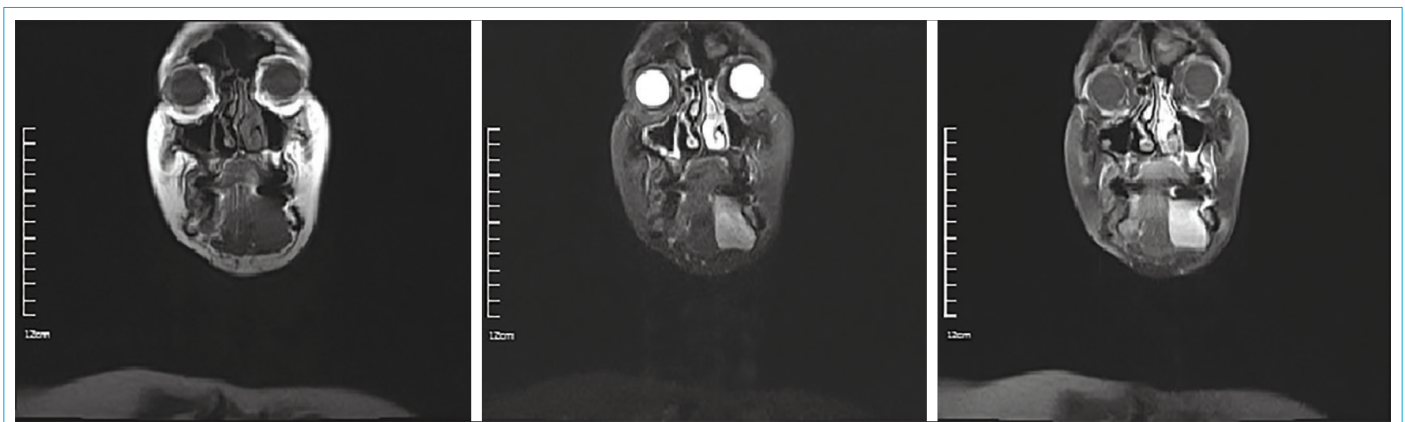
MR images of the mass. T1A, T2A and contrasted series, respectively.
